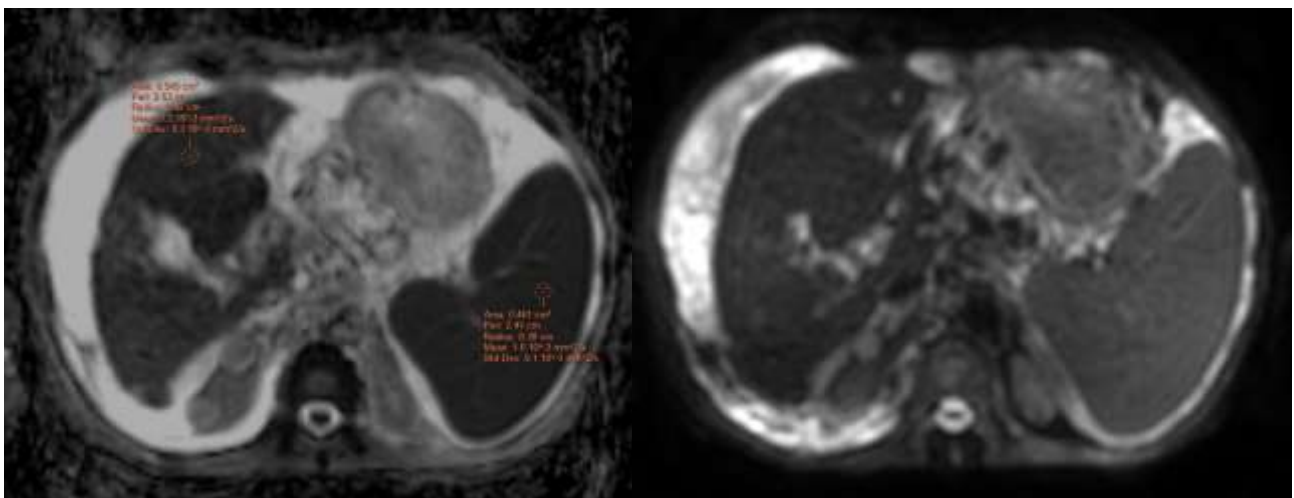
DWI and ADC MAPPING OF A CIRRHOTIC PATIENT
